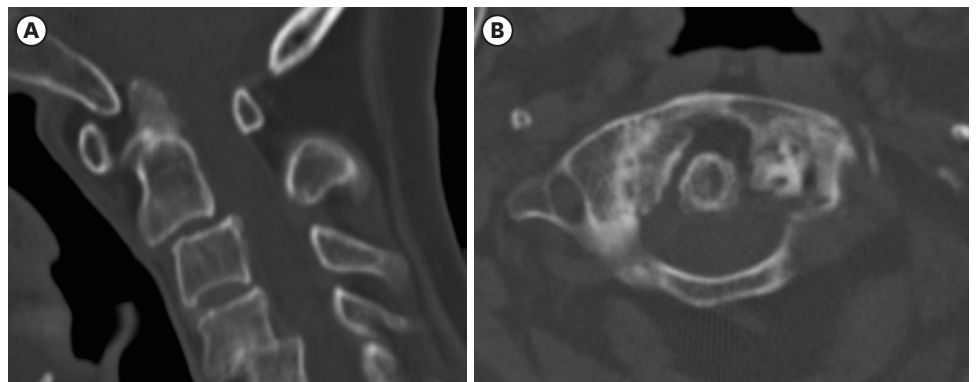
CT images. (A) sagittal view, (B) axial view. CT shows wide atlanto-dens interval and posterior atlanto-dens interval index.
